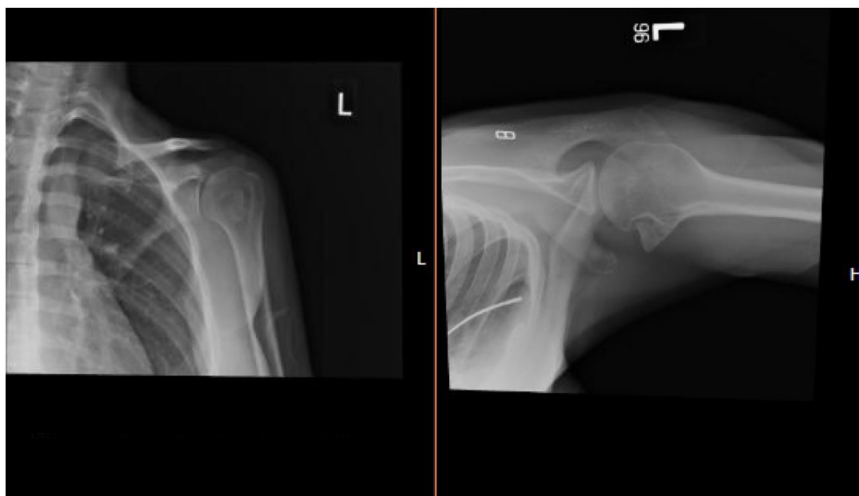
Preoperative anteroposterior and axillary radiographs taken 3 months after initial injury showing displacement of major fracture fragment.
